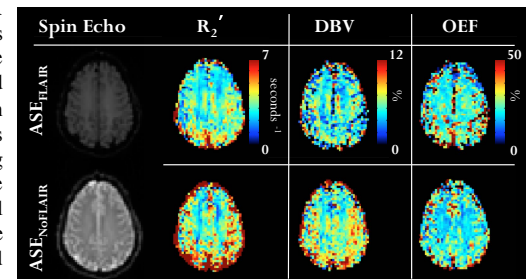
Example parametric maps (R_2' , DBV and OEF) from a single subject calculated using ASE_{FLAIR} (top row) and ASE_{NoFLAIR} (bottom row).
